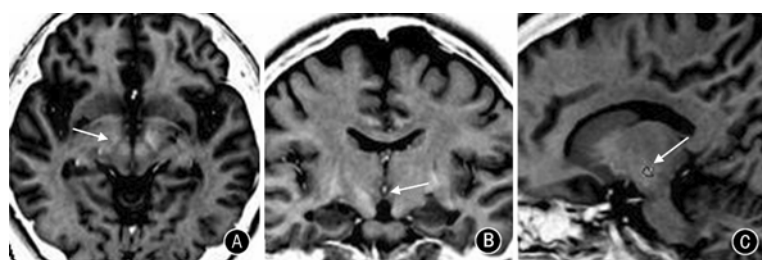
STN images on three different axes in stereotactic MRI. A: axial view; B: coronal view; C: sagittal view.
